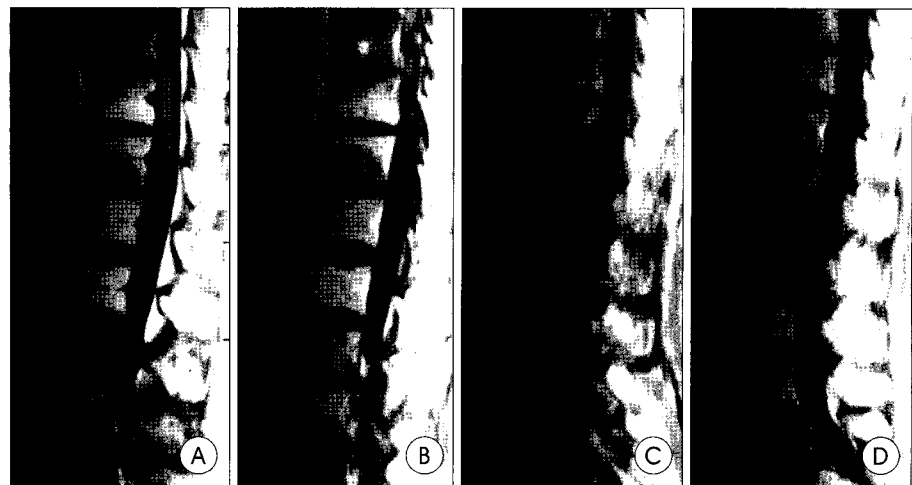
Symptomatic myeloma appearing as diffuse pattern of marrow involvement on T1 weighted sagittal magnetic resonance image of the lumbar spine (A). T1 weighted postcontrast image reveals diffuse enhancement of marrow (B). Symptomatic myeloma appearing as a variegated pattern of marrow involvement in lumbar spine (C). With gadolinium enhancement, it showing inhomogeneous enhancement throughout the lumbar spine (D).
